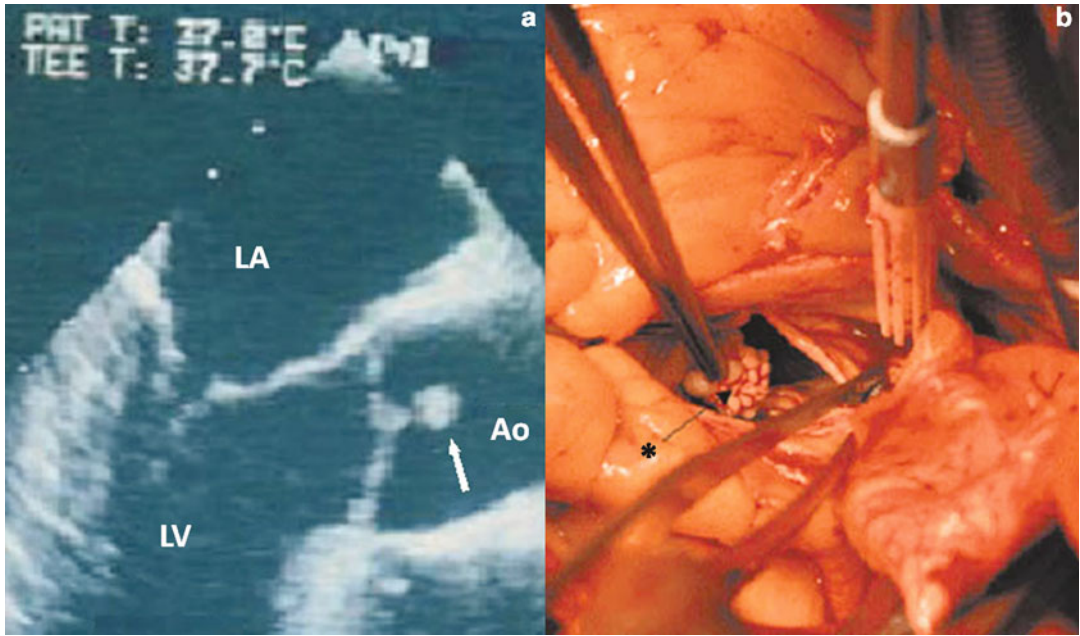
(a) Transesophageal echocardiogram of a papillary fibroelastoma attached to the aortic valve (arrow). Reprinted with permission of the Italian Society of Cardiology.
